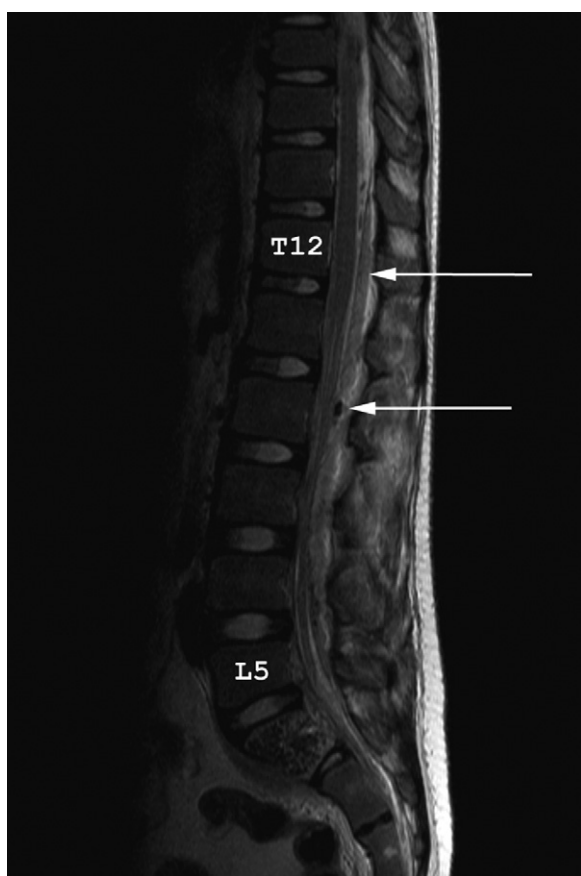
T2-weighted magnetic resonance image of the lumbar and sacral spine showing a posterior epidural abscess (top arrow) at the T12–S1 vertebral levels and epidural gas (bottom arrow).
